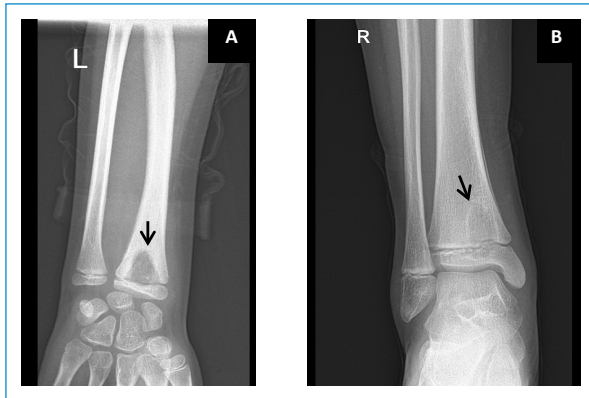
A: anteroposterior X-ray of the left forearm, showing a lytic lesion of the distal radio metaphysis (black arrow). B: anteroposterior X-ray of the right ankle, showing a lytic lesion of the distal tibia metaphysis with a sclerotic halo (black arrow) and periosteal reaction (white arrowhead).
